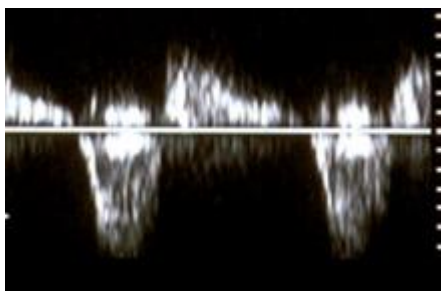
Doppler spectral waveform exhibiting to-and-fro flow pattern in the portal vein. This pattern suggests elevated portal venous pressure or right-sided heart failure.
